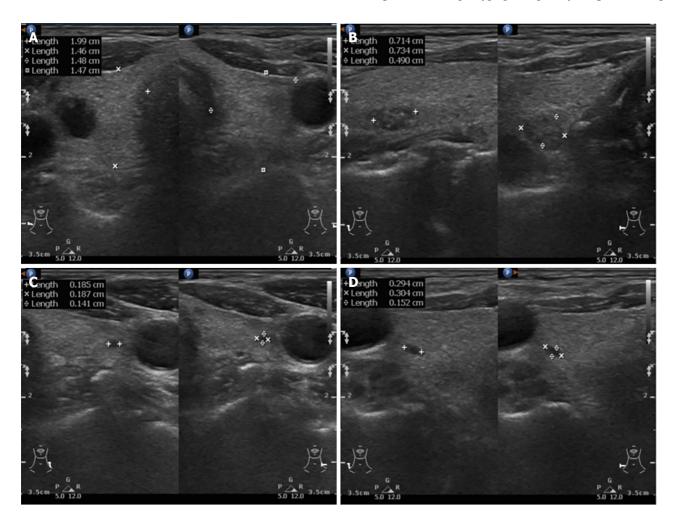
Neck sonography shows right and left lobe thyroid and multinodular goiter. A: Right and left lobe thyroid; B: Right side nodular goiter 0.73 cm × 0.49 cm × 0.71 cm; C: Left side nodular goiter 0.18 cm × 0.14 cm × 0.18 cm; D: Right side nodular goiter 0.30 cm × 0.15 cm × 0.29 cm.
